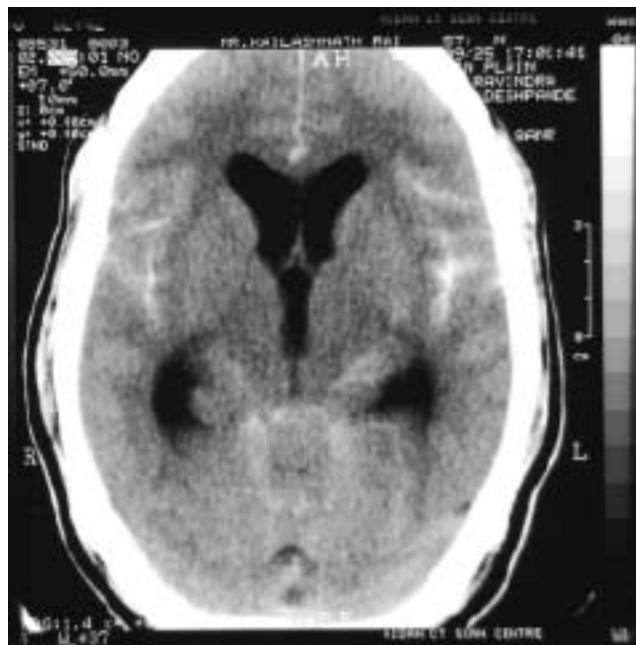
Non contrast CT Brain showing diffuse subarachnoid haemorrhage in the cisterns, sylvian fissures and parieto-occipital sulci.
